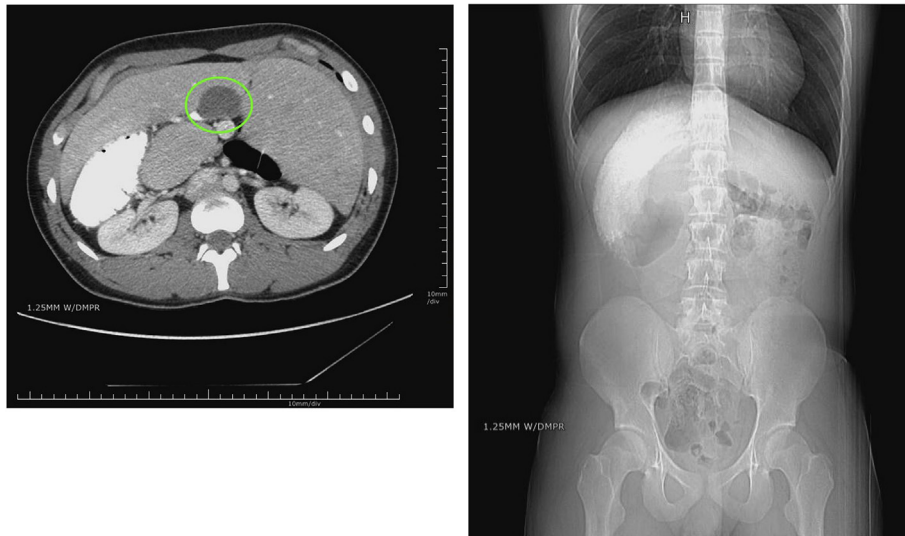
1.1. Abdominal CT, axial view, showing a midline liver and gallbladder (green circle). 1.2. Abdominal and pelvic x-ray showing the midline liver.
